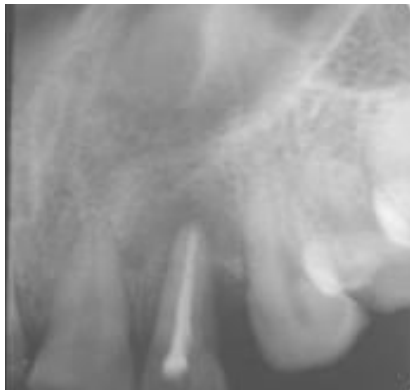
II(d). Post operative radiograph at the end of eighteen months.
